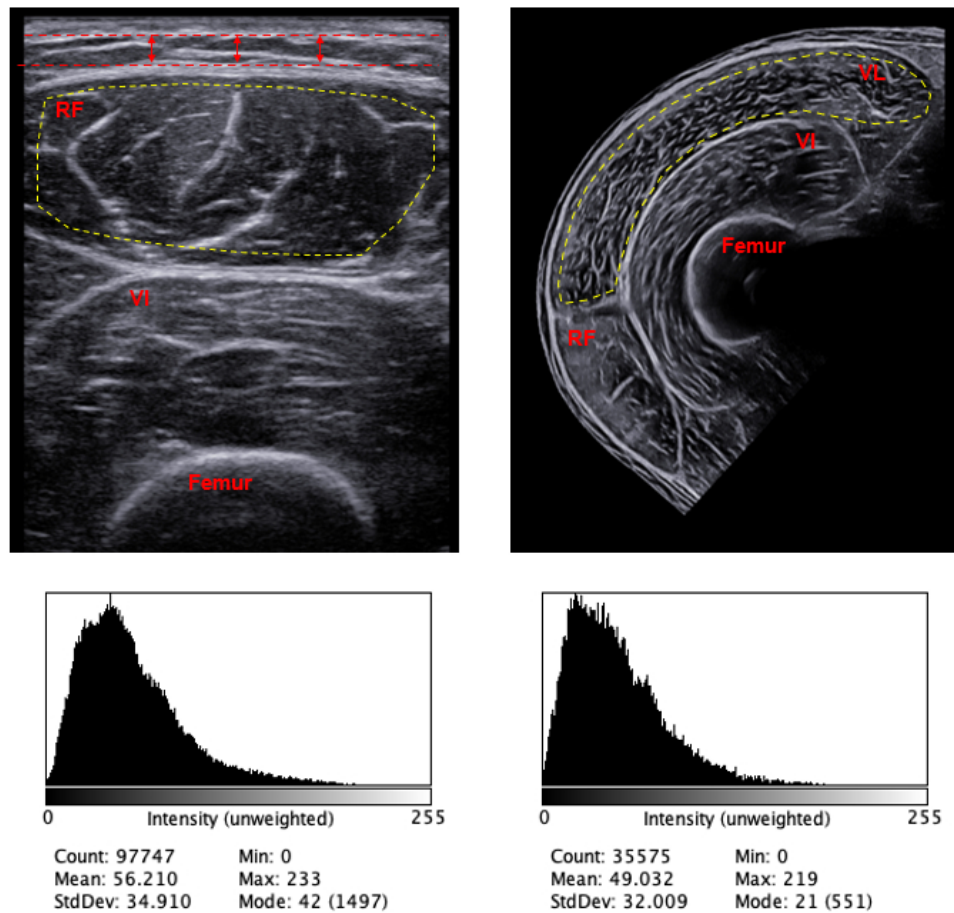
Example B-mode ultrasound image of the rectus femoris in the transverse plane (top left) and panoramic image of the vastus lateralis (top right) for assessment of skeletal muscle echo intensity together with the corresponding gray-scale pixel intensity histograms (below each image). Yellow dashed lines represent the region of interest used to determine echo intensity within the muscle belly. Red dashed lines indicate the borders of the dermal layer (top line) and the muscle aponeurosis (bottom line), and the red arrows represent the subcutaneous fat layer. Rectus Femoris, RF; Vastus Lateralis, VL; Vastus Intermedius VI.
